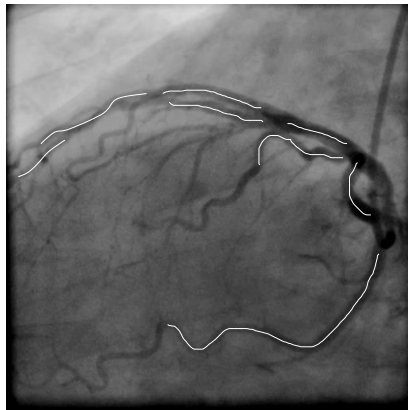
Example of manual annotated segments (in white) in a X-ray image.
